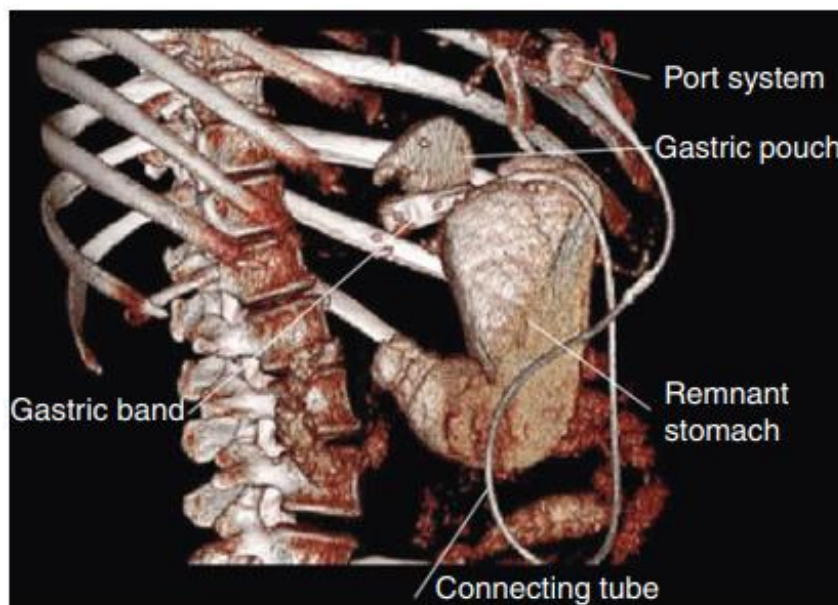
CT-reconstruction of a gastric band (*Korenkov et al., 2012*).
